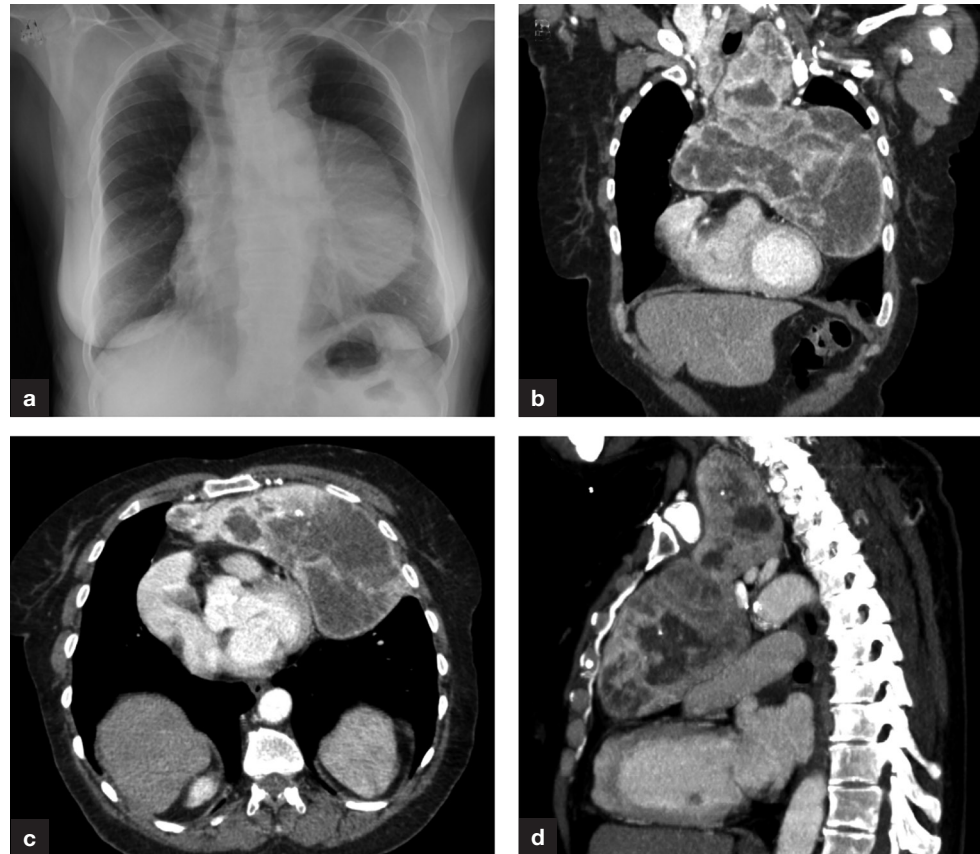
a. Postero-anterior lung X-ray shows a giant mediastinal and paracardiac mass. b. Coronal, (c) axial and (d) sagittal computed tomography scans reveal a giant retrosternal goitre with paracardiac extension.
